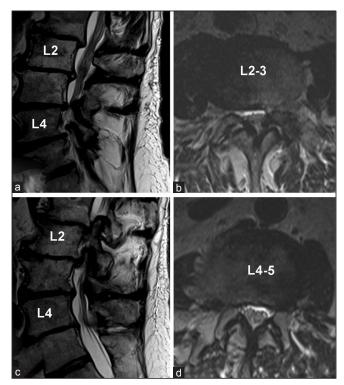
(a and c) Lateral and (b and d) anteroposterior views of lumbar magnetic resonance imaging with and without gadolinium contrast indicating the presence of moderate spinal and foraminal stenosis at L2-3 and L4-5. There is mild scoliosis indicating apparent severe central spinal stenosis that is not confirmed at adjacent scan
